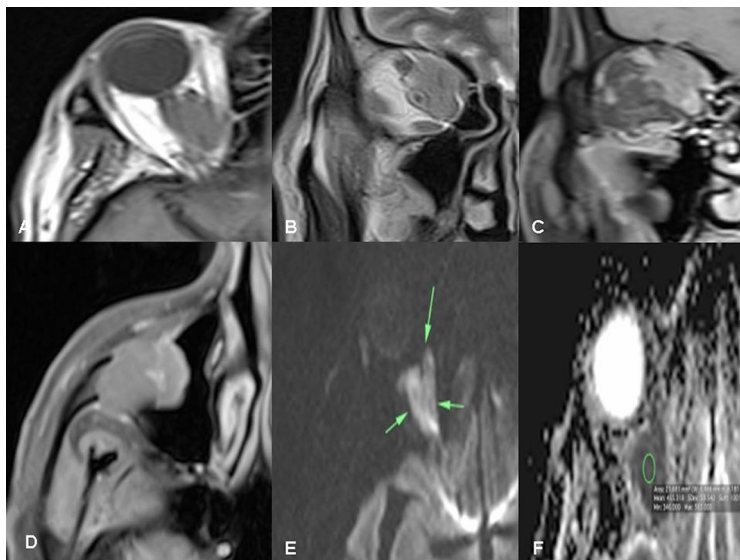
A 59-year-old female with right-sided dull aching orbital pain and limited right orbital movement. Axial T1 image A shows T1 hypointense infiltrative right retrobulbar intraconal mass involving the right medial rectus muscle, the related intraconal fat planes and inseparable from the optic nerve. Coronal T2 image B shows isointense signal of the lesion. Coronal T1 post-contrast image C reveals homogeneous enhancement of the retrobulbar lesion with possible invasion of the orbital roof. Axial T1 post-contrast image D shows similar infiltrative submucosal mass seen in the left maxillary sinus. Evident diffusion restriction on DWI (b_{1000})/ADC (E, F). The ADC value of $0.46 \times 10^{-3} \text{mm}^2/\text{sec}$. E Pathologically proved right-sided retrobulbar lymphoma (NHL) partially encasing the left optic nerve
